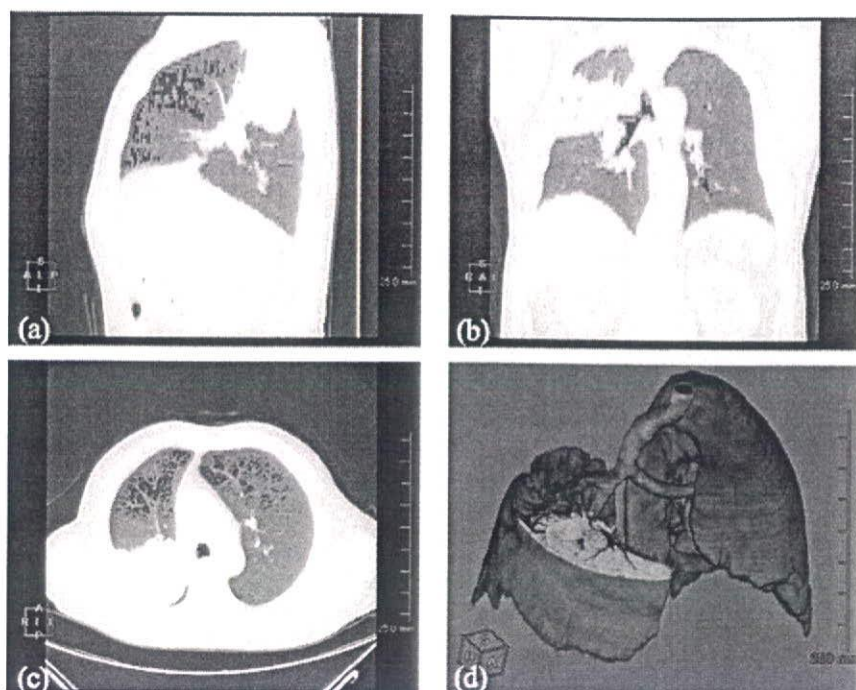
Quantitative CT in a patient with lung cancer at the hilum of the right upper lobe associated with its peripheral atelectasis. The area with green color shows lung parenchyma with a range between -910 and -500 HU. The right upper lobe outside of the tumor and atelectasis showed an area without green color due to emphysema. (a) sagittal; (b) coronal; (c) axial; and (d) 3D imaging after virtual lobectomy.
